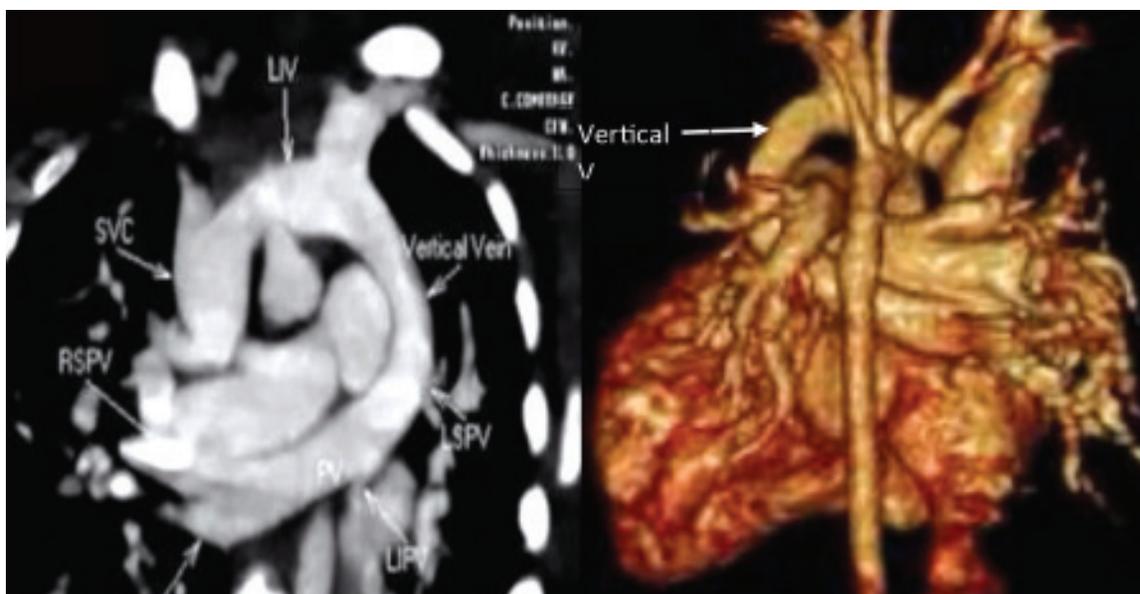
CT angiogram showed all pulmonary veins draining to vertical vein to SVC to RA.
